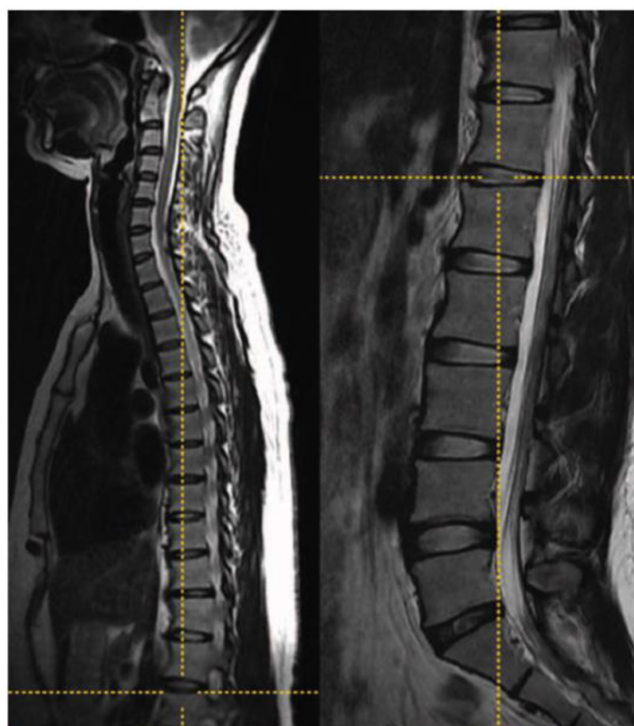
A case of L6 vertebra with type IIa transition. Left, T2-weighted sagittal cervicothoracic and (right) lumbar images in the cross-referencing mode of the picture archiving and communication system. This simultaneously demonstrates the marker at the T12–L1 disc space. Counting the vertebral levels caudally from C2 reveals this patient to have 25 presacral vertebrae or 6 lumbar vertebrae.⁵
